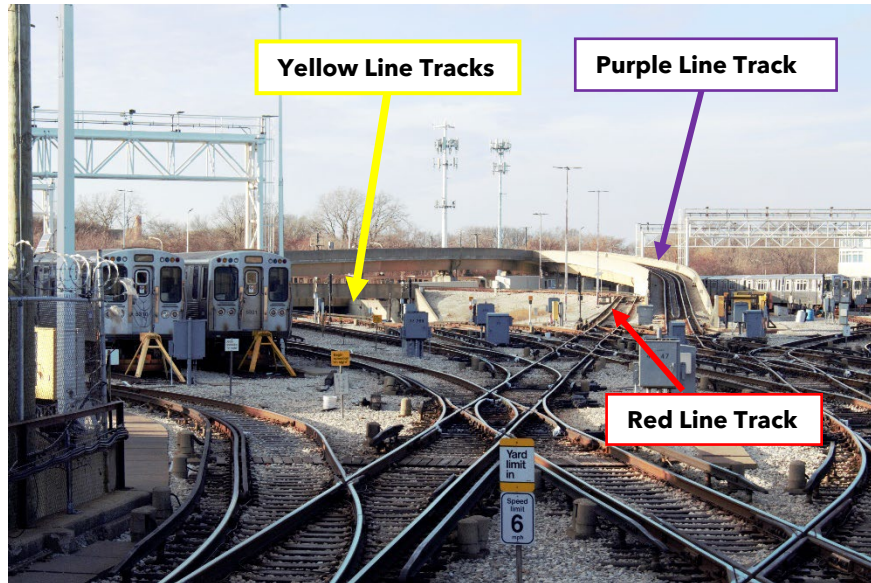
Photograph taken from the Howard Avenue CTA station platform looking northward into the Howard Yard. The Yellow Line, Red Line and Purple Line tracks are highlighted. (Source: NTSB)
